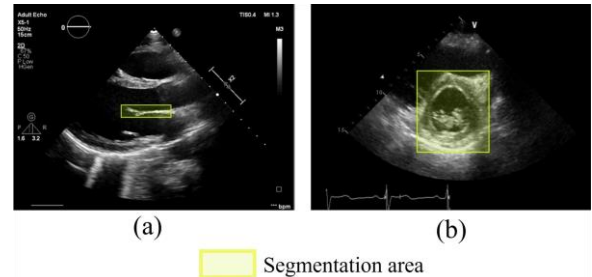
Example of annotation of the object detection model (a) mitral valve (b) the left ventricular region in the parasternal short-axis view at the level of the mitral valve
